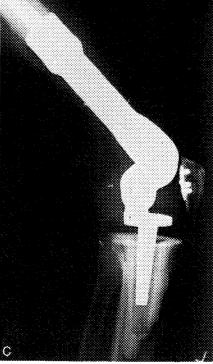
Malignant fibrous histiocytoma of bone (stage IIB). A 64-year-old man presented with pain about his knee of 3 months duration. A, A lateral radiograph demonstrating a destructive permeative lesion involving the metaphyseal region of the distal femur. There is cortical destruction anteriorly and a soft-tissue mass. B, A sagittal magnetic resonance scan shows the intramedullary extent of the tumor and a soft-tissue extension within the knee joint. C, A lateral radiograph I year later shows the results of a wide resection and reconstruction with a customized total knee replacement.
